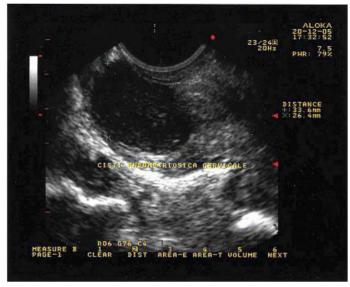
ultrasonographic image of cervical cystic-nodule of endometriosis
